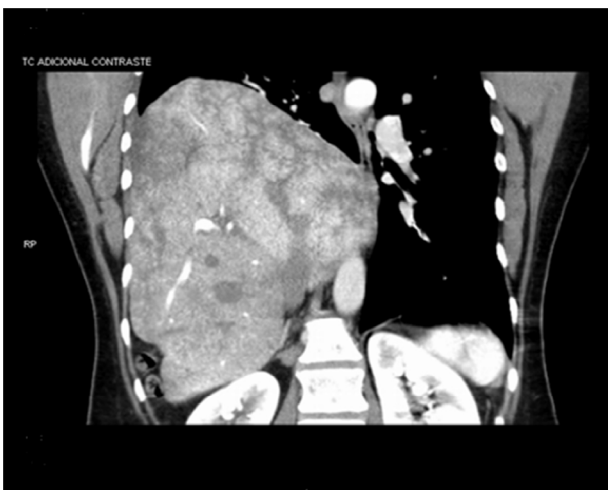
Diagnosis confirmed by axial CT: diaphragmatic hernia with almost complete herniation of the liver into the right hemithorax.
